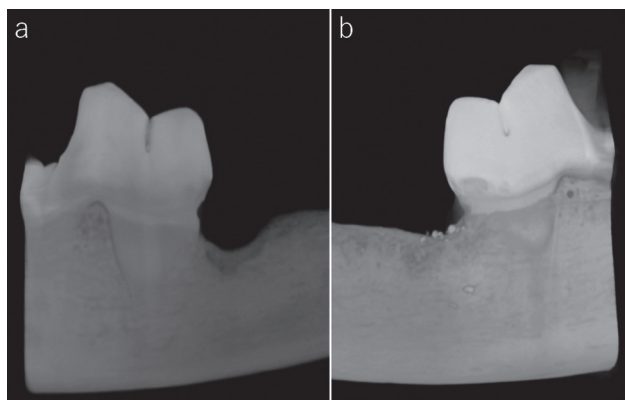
Three-dimensional image taken by microfocus computed tomography.
